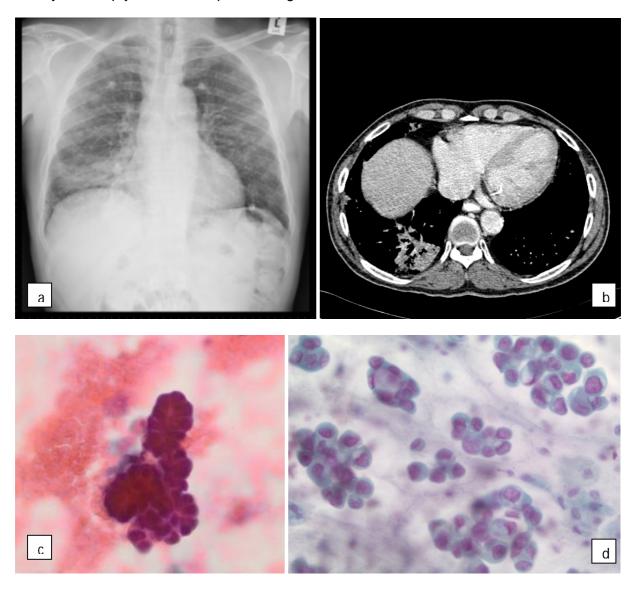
Right middle lobe consolidation with extensive lymphadenopathy on chest X-ray (a) and CT (b). Sputum – malignant. Small, degenerate cells forming acini (c). FNA - Well differentiated adenocarcinoma with mucin in the background, papillary structures and vacuolated cytoplasm; features similar to a BAC (d).
